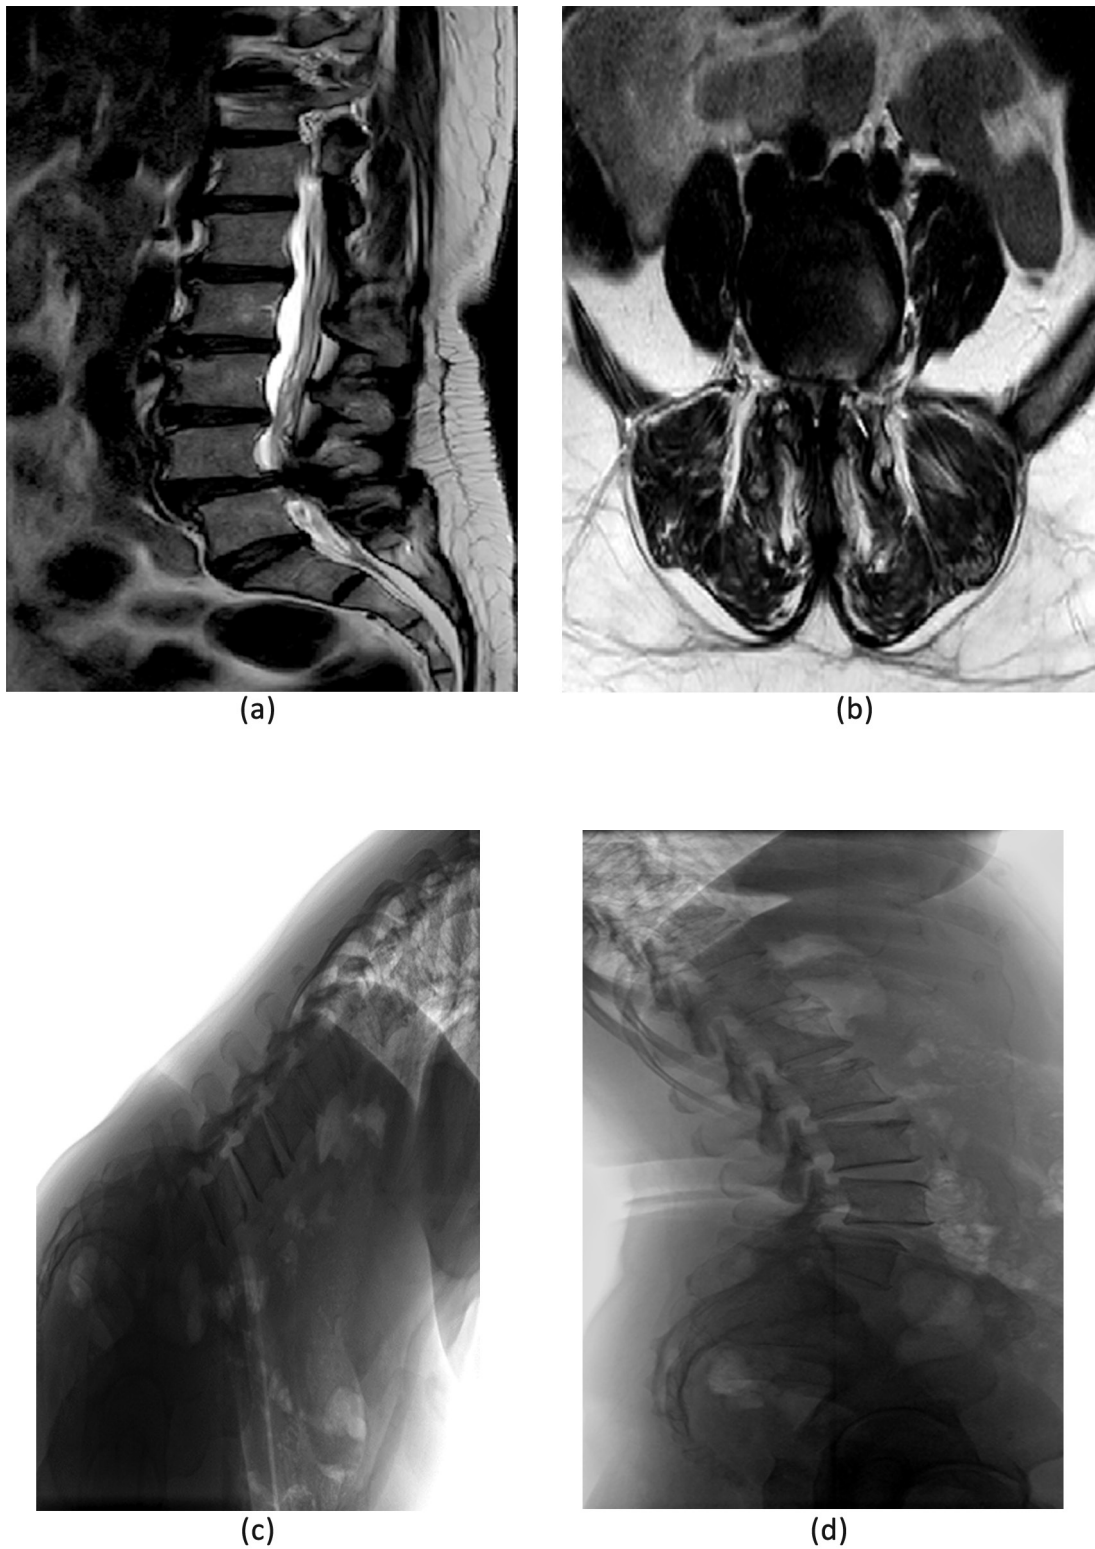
a: MRI Sagittal view, b: MRI axial view, c: Flexion view LS spine, d: Extension view LS spine
